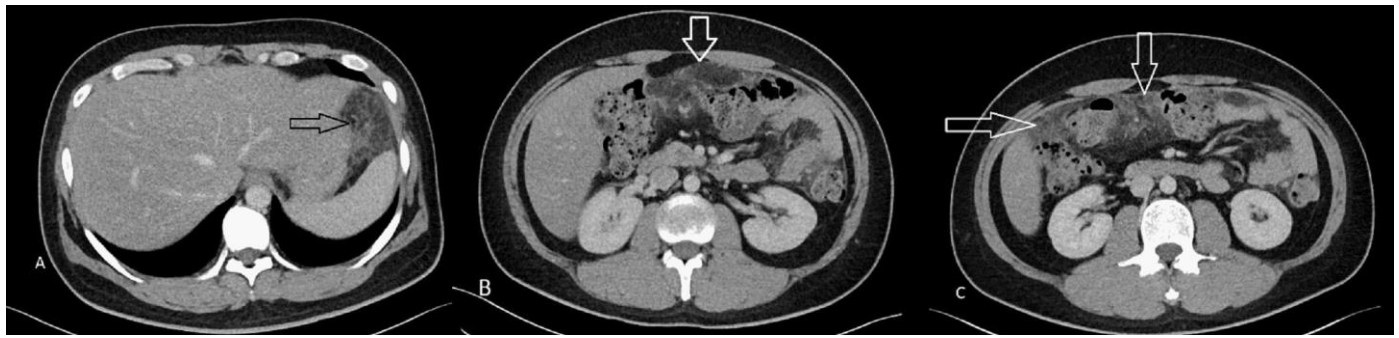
A 30-year-old-gentleman with SPTCL having refractory disease on the follow-up scan despite changing to a new, second round of chemotherapy regime. Contrast-enhanced computed tomography of the abdomen/pelvis.
